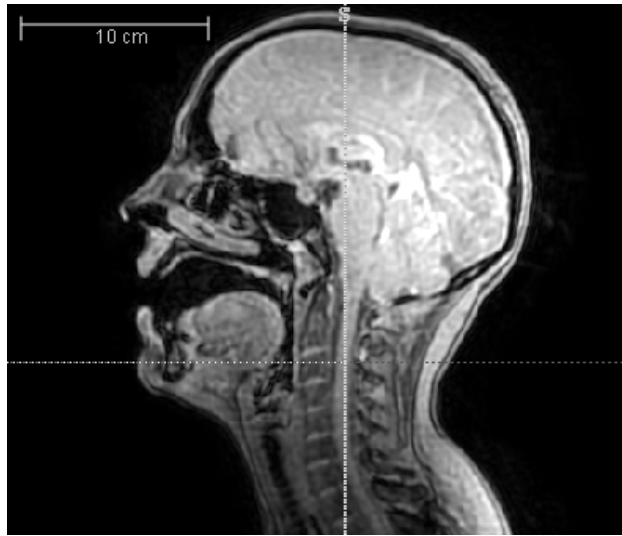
an example of MRI of vocal tract.
